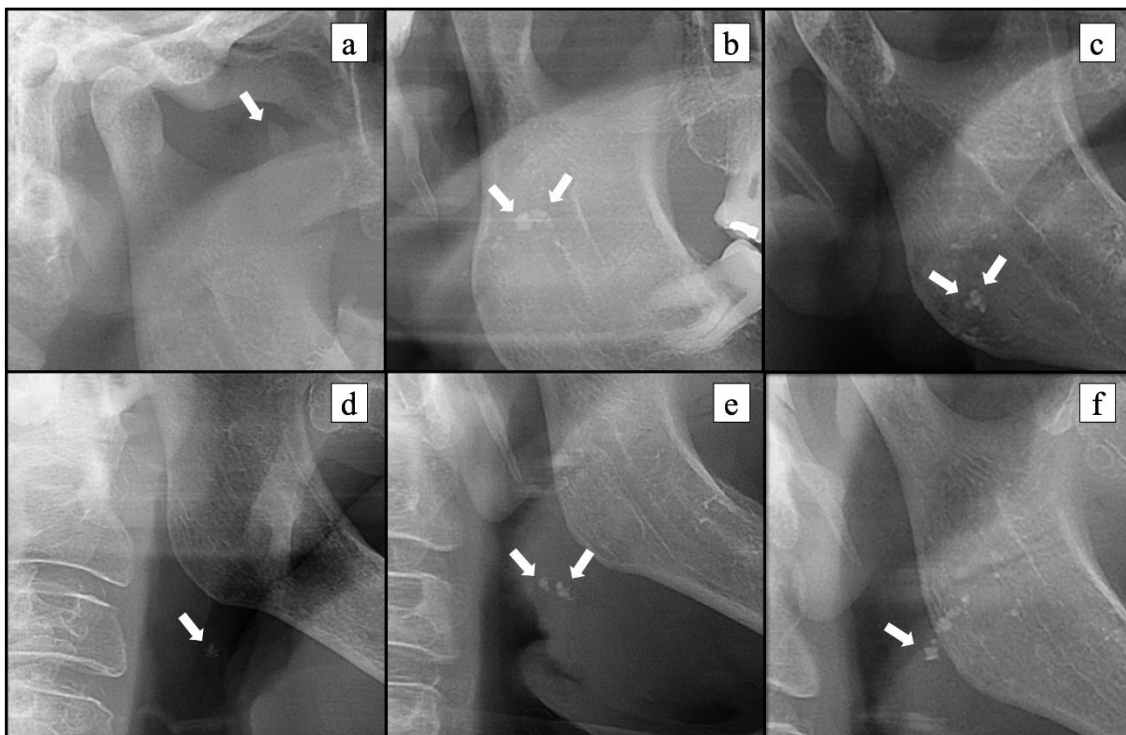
Panoramic radiographs showing the presence of tonsilloliths (white arrow) according to the regions (Takahashi et al., 2017): (a) Region 1; (b) Region 2; (c) Region 3; (d) Region 4; (e) Region 5; (f) Region 6.
